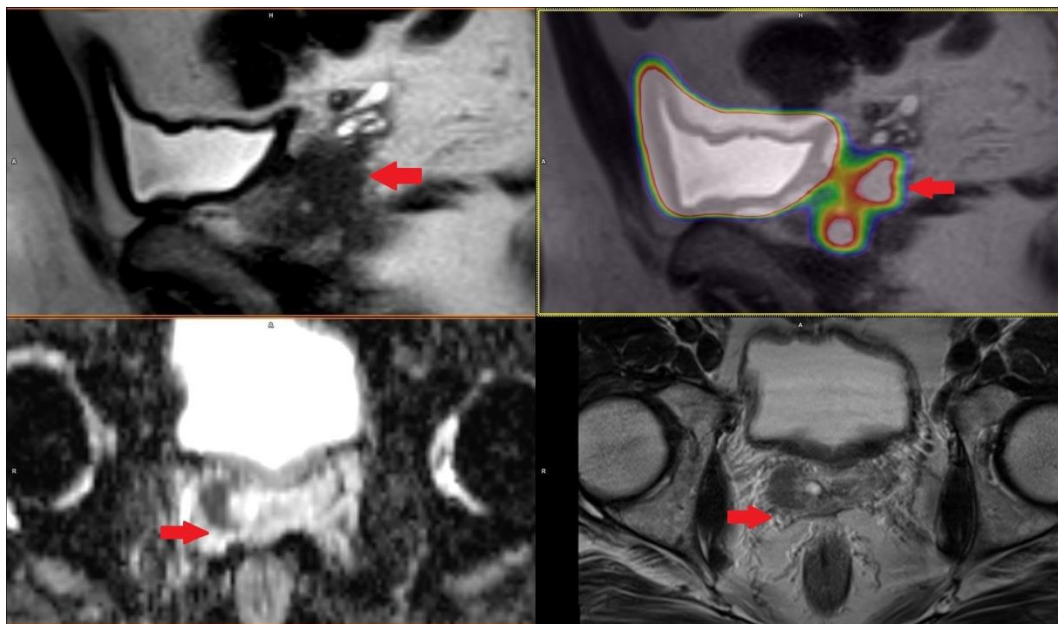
Patient with prostate cancer GS 7 (4 + 3) in right lobe with right seminal vesicle invasion cT3b iPSA 4.17 PHI 64.93 in ^{68}Ga -PSMA-11 PET/MRI.
